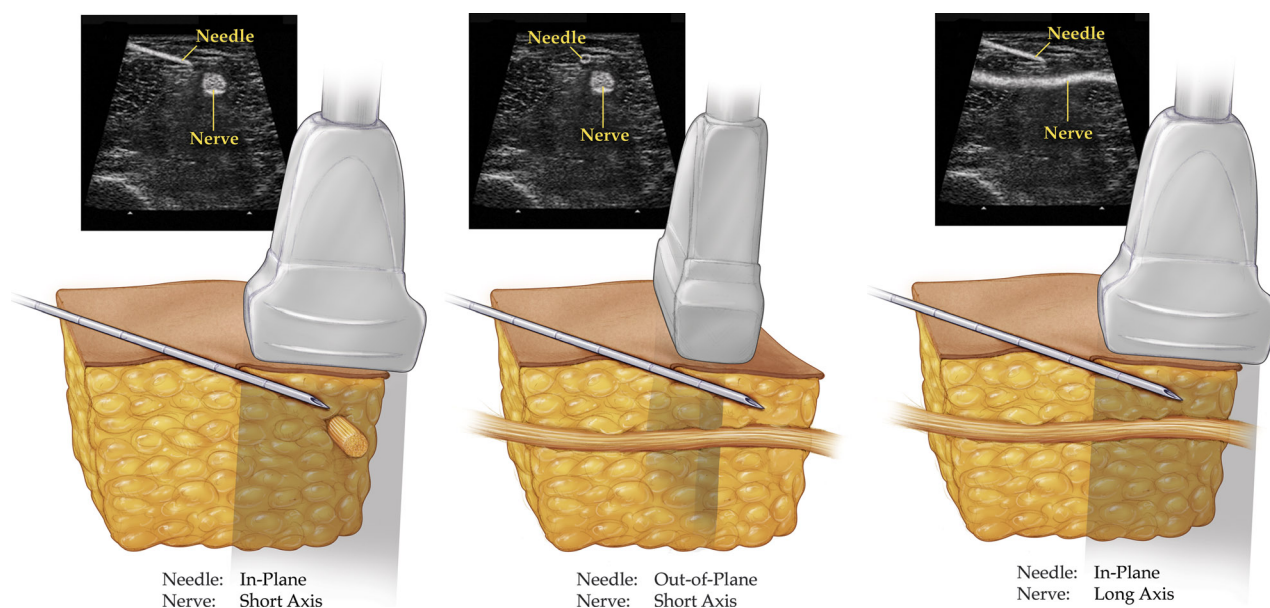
Various ultrasound-guided perineural catheter insertion approaches: needle within the ultrasound plane and target nerve in cross section or short axis (left), needle out-of-plane and target nerve in short axis (middle), and both the needle and target nerve within the ultrasound plane (right).
